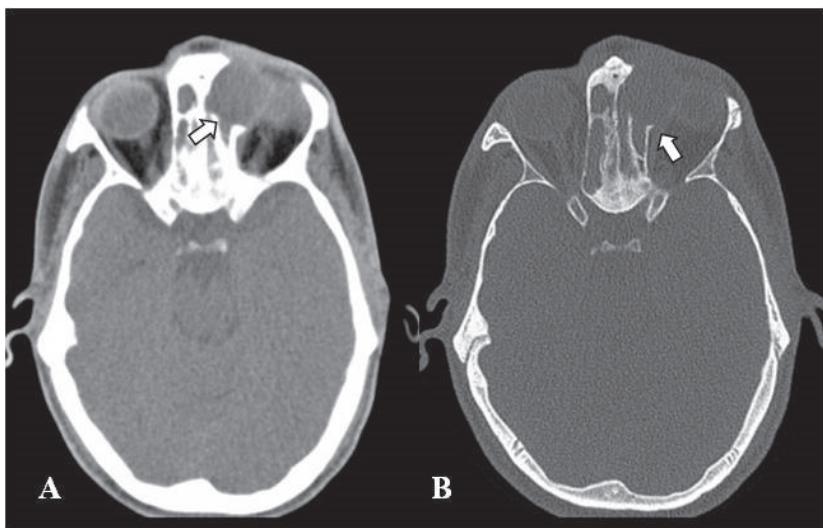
Fronto-ethmoidal mucocele in a patient with proptosis and diplopia. (A) CT – heterodense lesion eroding the anterior ethmoidal cells and the floor of the frontal sinus entering the orbit from medio-cranial direction (white arrows).
